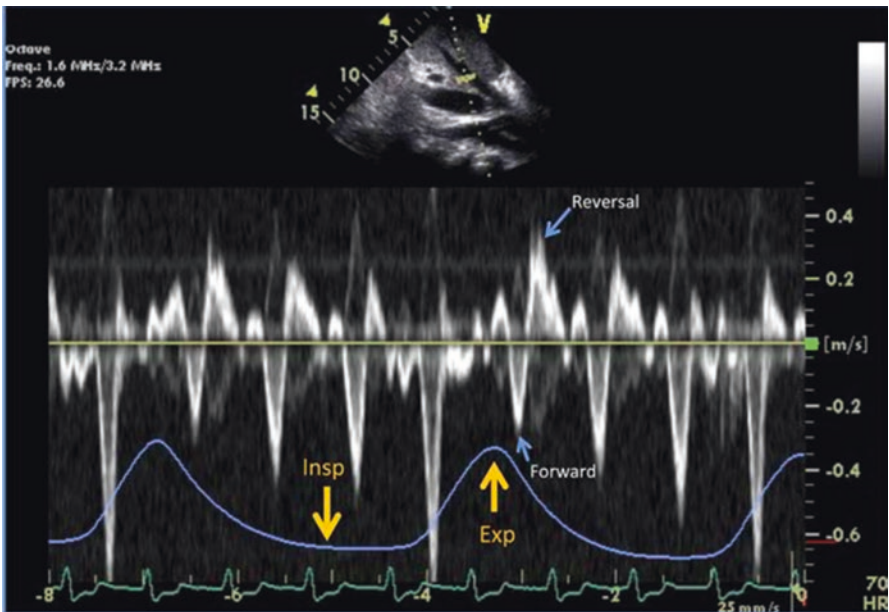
Hepatic vein flow reversal in tamponade. Pulsed-wave Doppler recording (subcostal window) within the hepatic vein with a prominent diastolic flow reversal in expiration. Reproduced with permission from [13]
